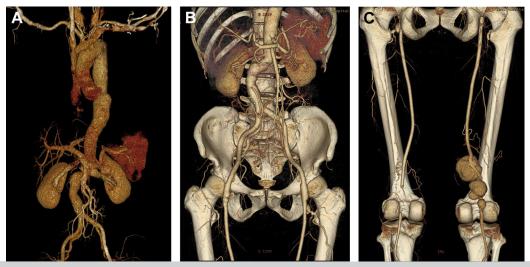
Computed tomography angiography (CTA) revealed formation of multiple aneurysms in thoracic aorta (A and B, maximum diameter, 45 mm), abdominal aorta (A and B; maximum diameter, 32 mm), bilateral common femoral artery (B; maximum diameter, 15 mm), and right popliteal artery (C; maximum diameter, 60 mm).
